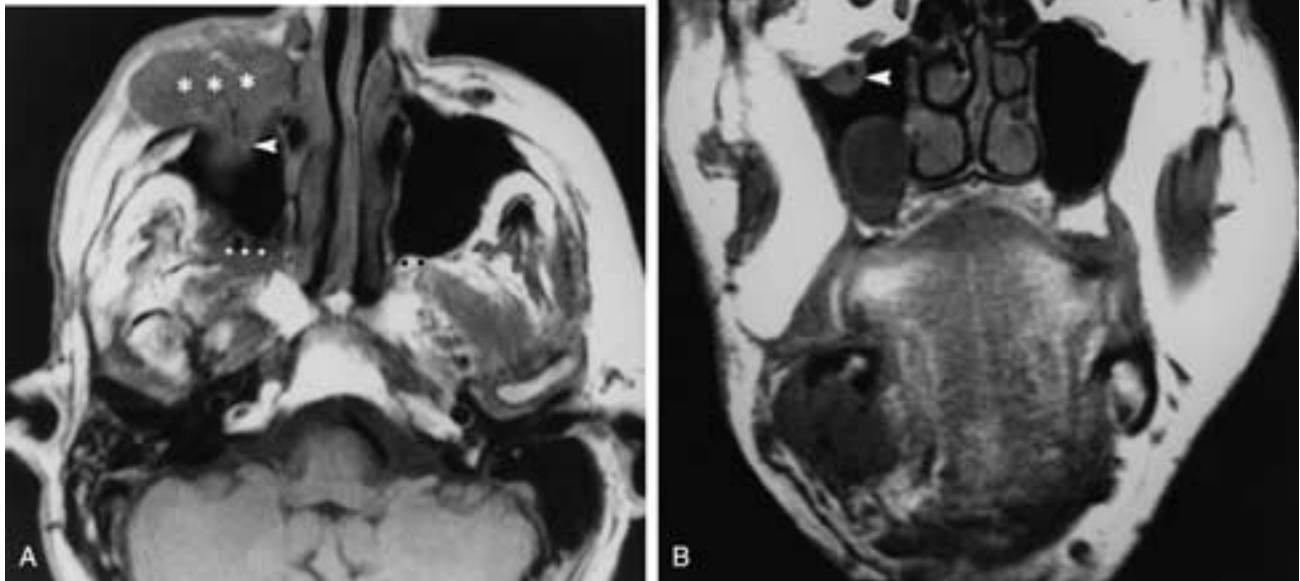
Recurrent desmoplastic melanoma in multiple facial locations with PNS along the zygomatic and infraorbital branches of the maxillary nerve (V_2). A, Axial T1-weighted MR image shows large right-sided cheek recurrence (asterisks) spreading posteriorly along the infraorbital nerve (arrowhead). Tumor can be seen widening and replacing the expected hyperintense fat within the right PPF (white dots). Note the normal hyperintense fat in the left PPF (black dots). B, Coronal T1-weighted MR image shows a grossly enlarged right infraorbital nerve representing perineural spread (arrowhead). Note the right-sided tumor recurrence in the temporal region (asterisks). The lateral intraorbital mass (arrow) likely represents PNS along the zygomaticotemporal/zygomaticofacial branches of V_2 (see Fig. 13-3). (From Ginsberg LE. Imaging of perineural tumor spread in head and neck cancer. *Semin Ultrasound CT MR* 1999;2:175–186.)
